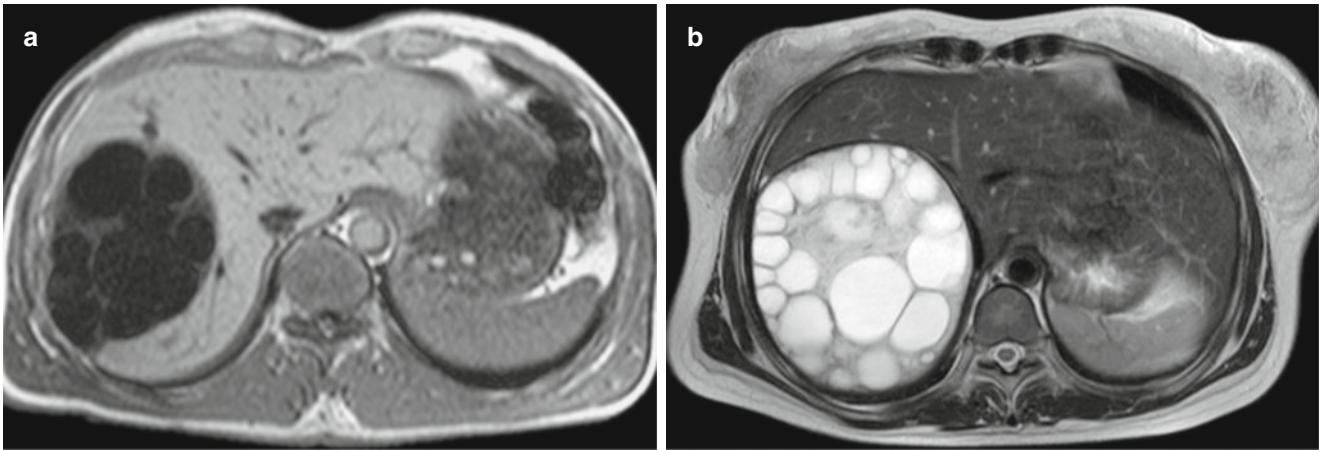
Hepatic cystic hydatidosis (multiple daughter cyst type). (a) By T1WI of MR imaging, hepatic cyst is demonstrated in the right liver lobe, with daughter cysts arranged along the mother cyst wall in rose petal sign. (b) MR hydrography provides more direct view of the lesion
